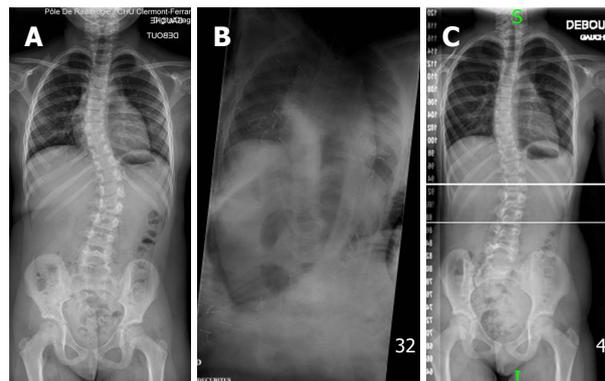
Pre-operative (A) and postoperative (B, C) radiographs in a 7-year-old girl with infantile and juvenile scoliosis. Forty degree lumbar deformity with 25° thoracic compensatory curve (A); after cast application, the spine is fully corrected (B); Two point five years after cast removal, the deformity has reduced to 20° in both the lumbar and thoracic spine (C).
